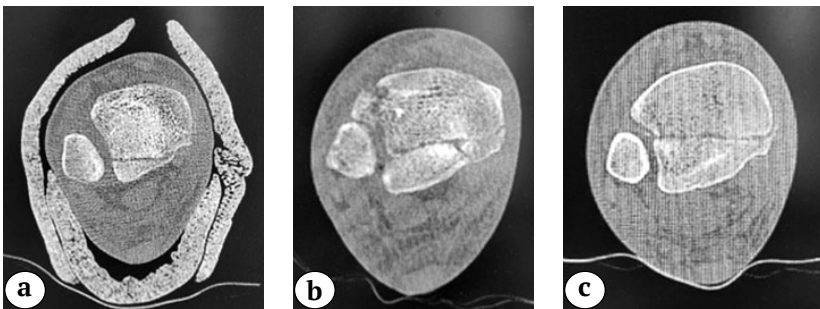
Differences in the size of the tibia posterior edge fragment on axial CT sections of different patients: a – intra-incisural posterolateral fragment involving 1/3–1/4 fibular incisura (type 2 according to J. Bartoniček et al.); b – intra-incisural posteromedial two-fragmental fracture, including the posterior part of the fibular incisura laterally and the posterior part of the medial ankle medially (type 3 according to J. Bartoniček et al.); c – large posterolateral fragment of triangular shape, including the posterior half of the fibular incisura (type 4 according to J. Bartoniček et al.)
